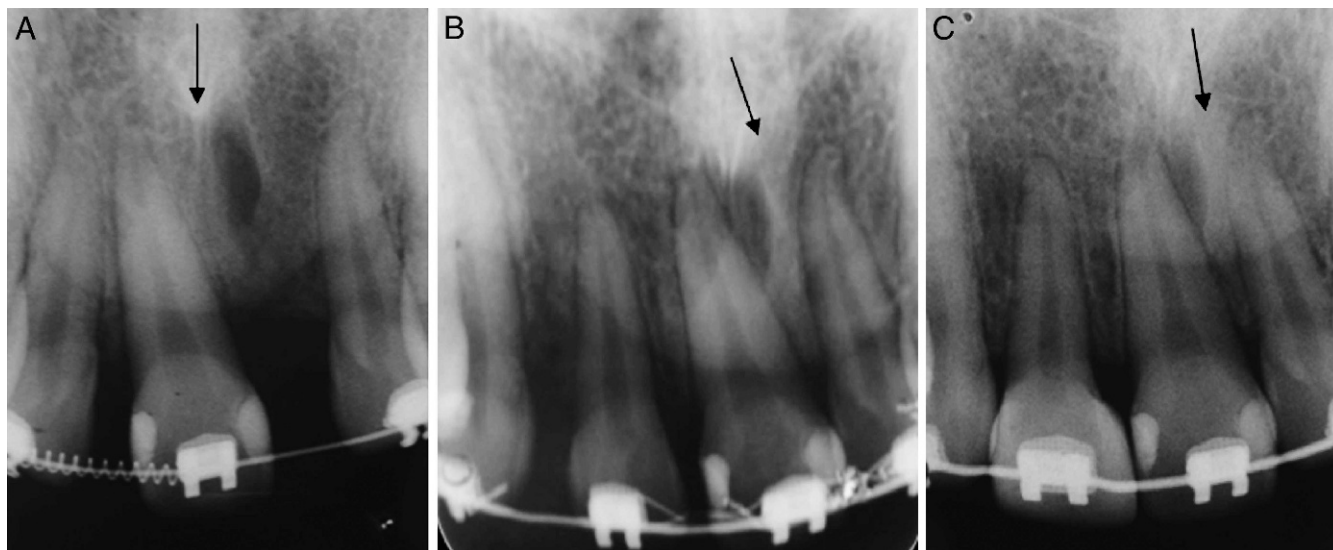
Sequence of periapical radiographs showing that the midpalatal suture deviated to the left following the central incisor movement (arrows).
